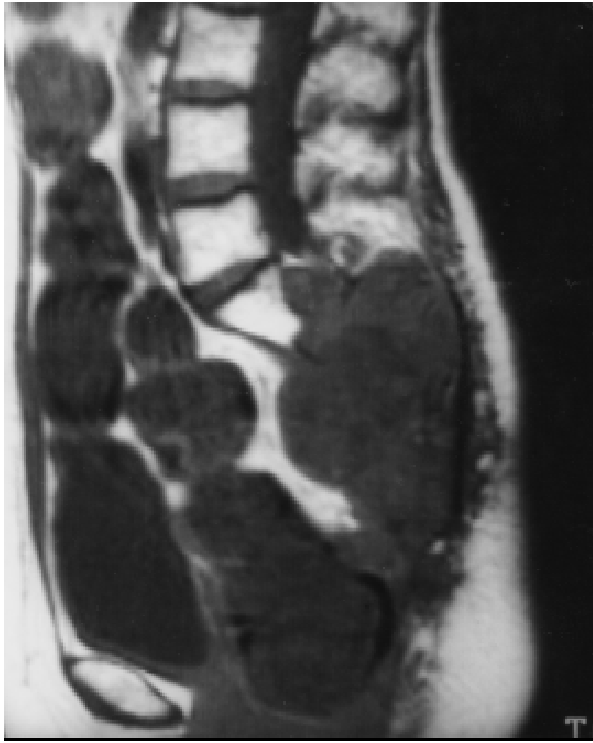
Case 9. T1-weighted magnetic resonance image of the sagittal plane. The low signal intensity tumor mass infiltrated in the upper part of the sacrum with producing an extraskelatal tumor component.
